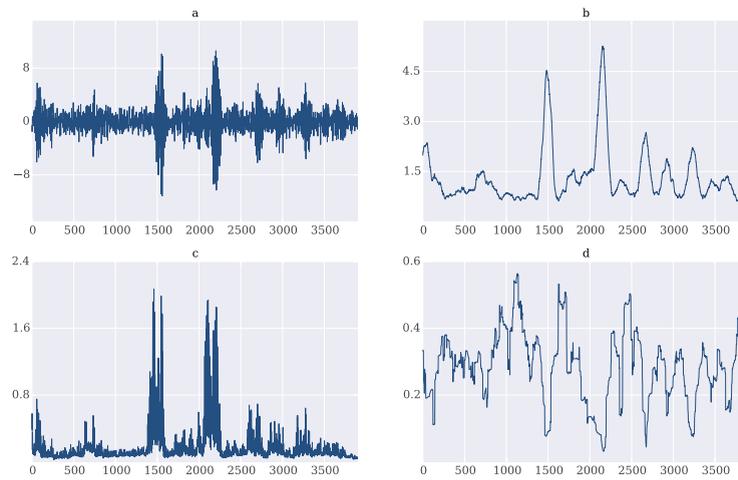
(a) Doppler data; (b) absolute values of Doppler signal with moving average filter; (c) AR coefficients; (d) instantaneous frequency with moving average filter.
